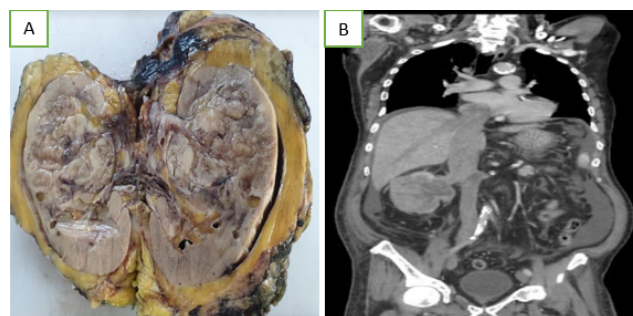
A: Gross morphology. Large tumor having grey white solid appearance with areas of hemorrhage; B: Contrast -enhanced computed Tomography abdomen showing the right kidney with ill defined heterogeneously enhancing mass lesion. Tumor is seen infiltrating in to the renal vein with evidence of IVC thrombus extending cranially to atriocaval junction and till the right atrium. Caudally thrombus was extending to the confluence of common iliac veins.
